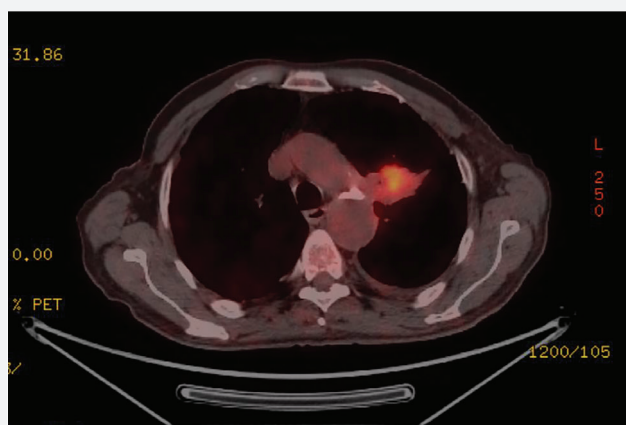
PET-CT image after treatment (20/09/2024) showing the responding lesion in the lung
